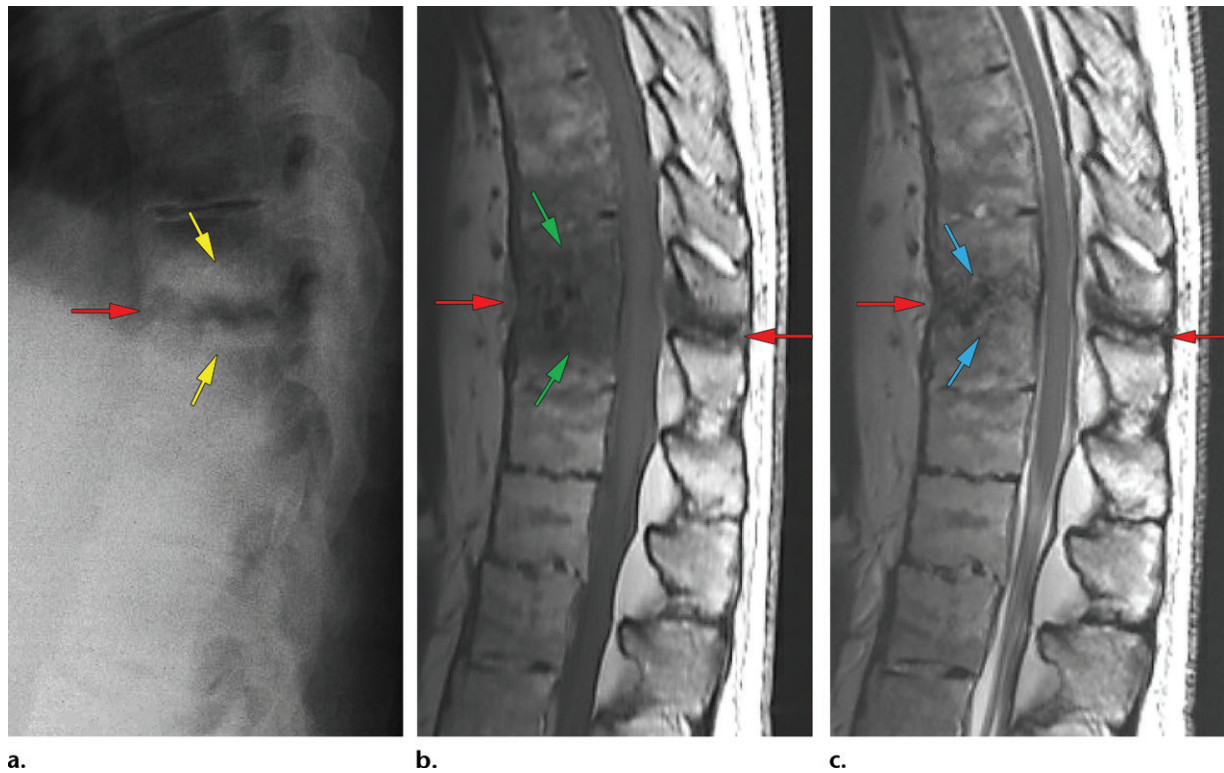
Classic Andersson lesion in a 48-year-old man with AS. (a) Lateral radiograph shows the transdiscal fracture at T10-T11 (red arrow), with destructive changes of the surrounding vertebral bodies, and reactive sclerosis (yellow arrows), a finding that represents pseudarthrosis from nonunion. (b) Sagittal T1-weighted MR image shows the hypointense transdiscal fracture (red arrows) extending to the posterior elements. The reactive inflammatory changes to the bone (green arrows) surrounding the fracture line are T1 hypointense. (c) Sagittal T2-weighted MR image shows the hypointense transdiscal fracture extending to the posterior elements (red arrows). The reactive inflammatory changes (blue arrows) to the bone surrounding the fracture line are mildly T2 hyperintense.
